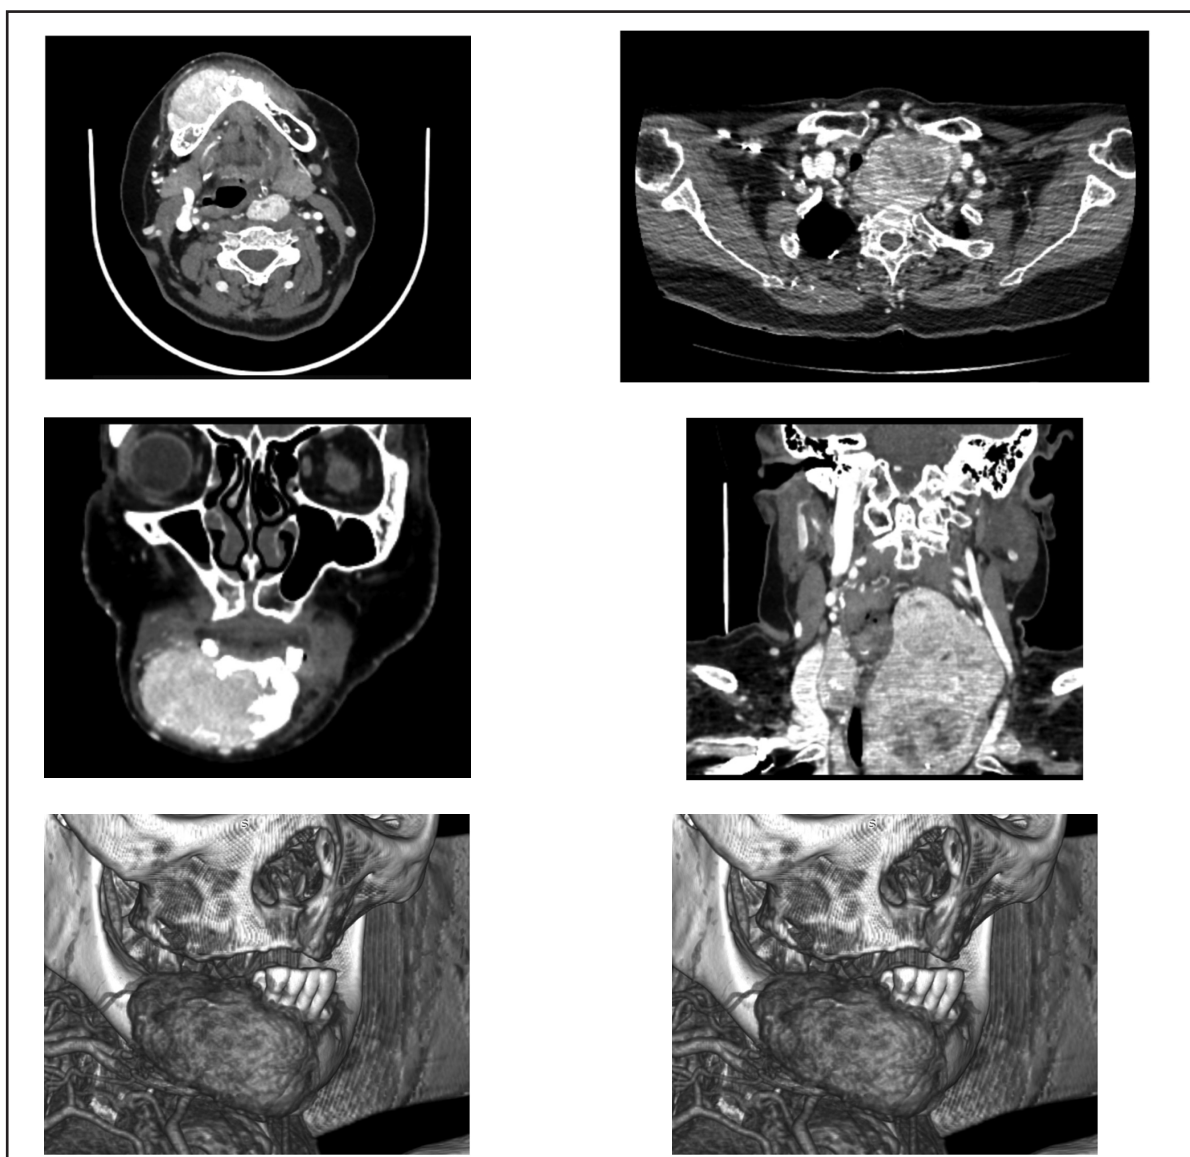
CT scan images of the anterior neck mass and mandibular mass [Axial view (top left and right), coronal view (middle left and right), 3D reconstruction of the mandibular mass (bottom left and right)]
